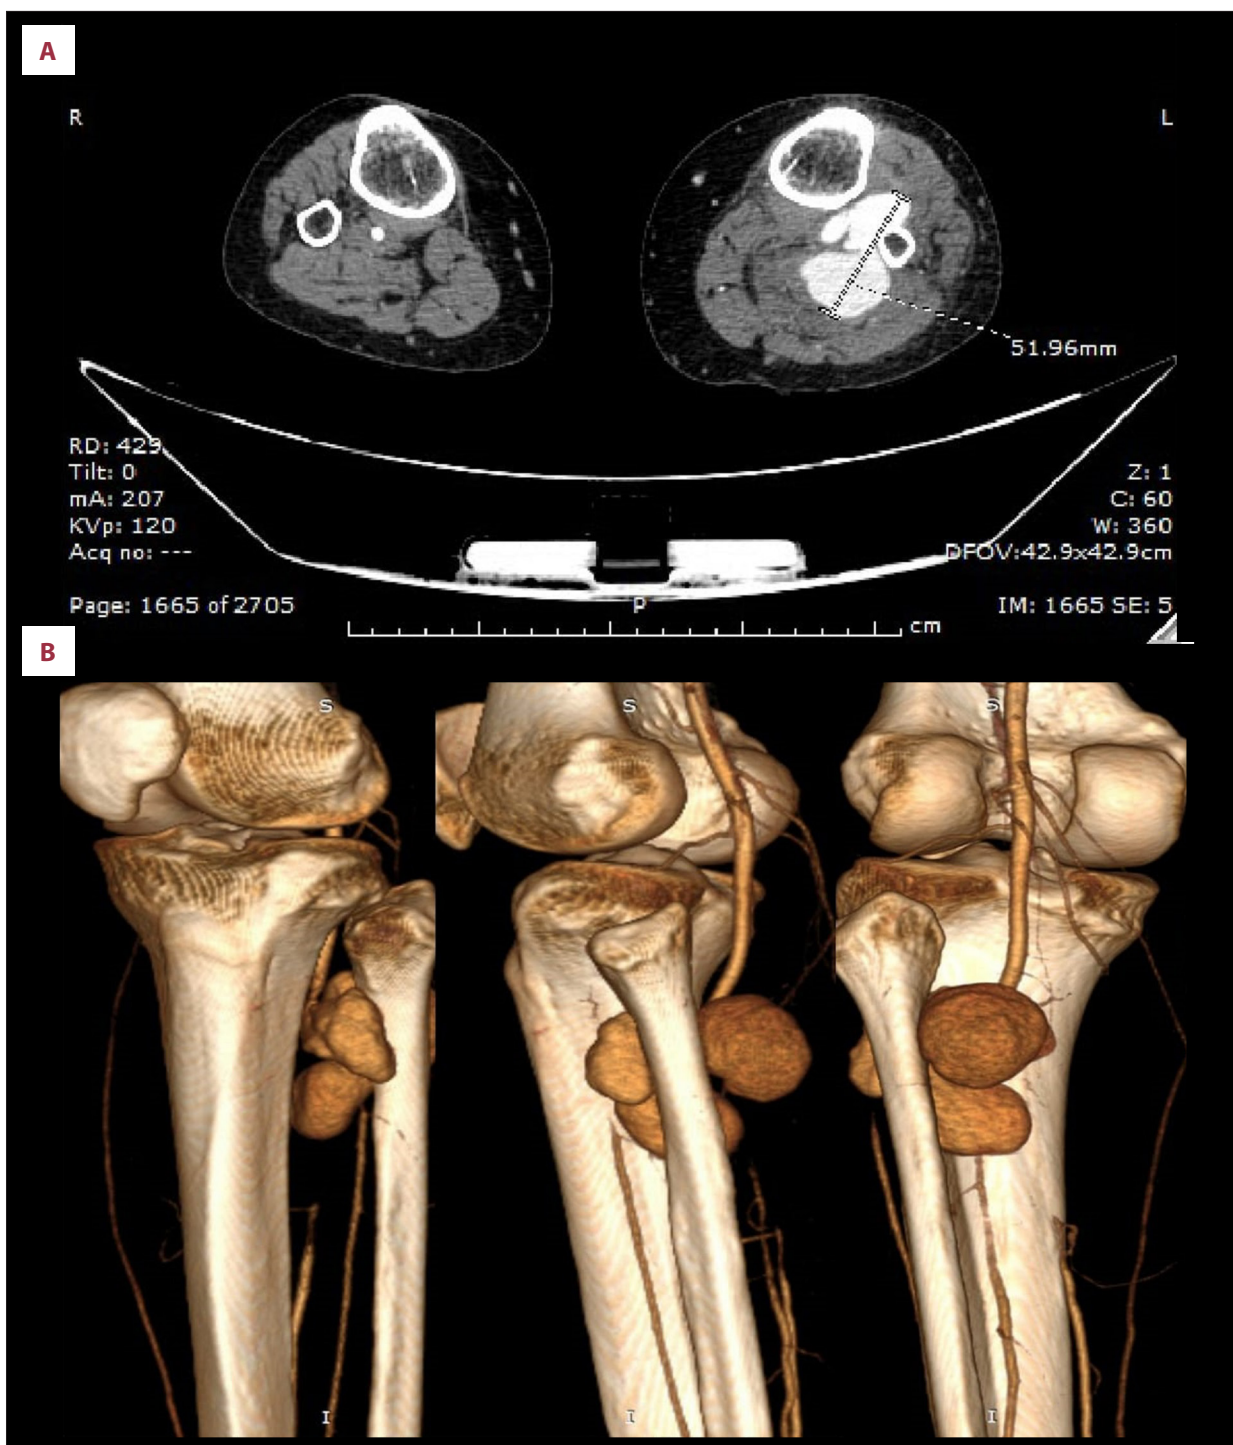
Pre-operative CTA of the left lower extremity: (A) Axial image showing pseudoaneurysm involving posterior and anterior compartment; (B) 3-D images reconstructed with different views.
